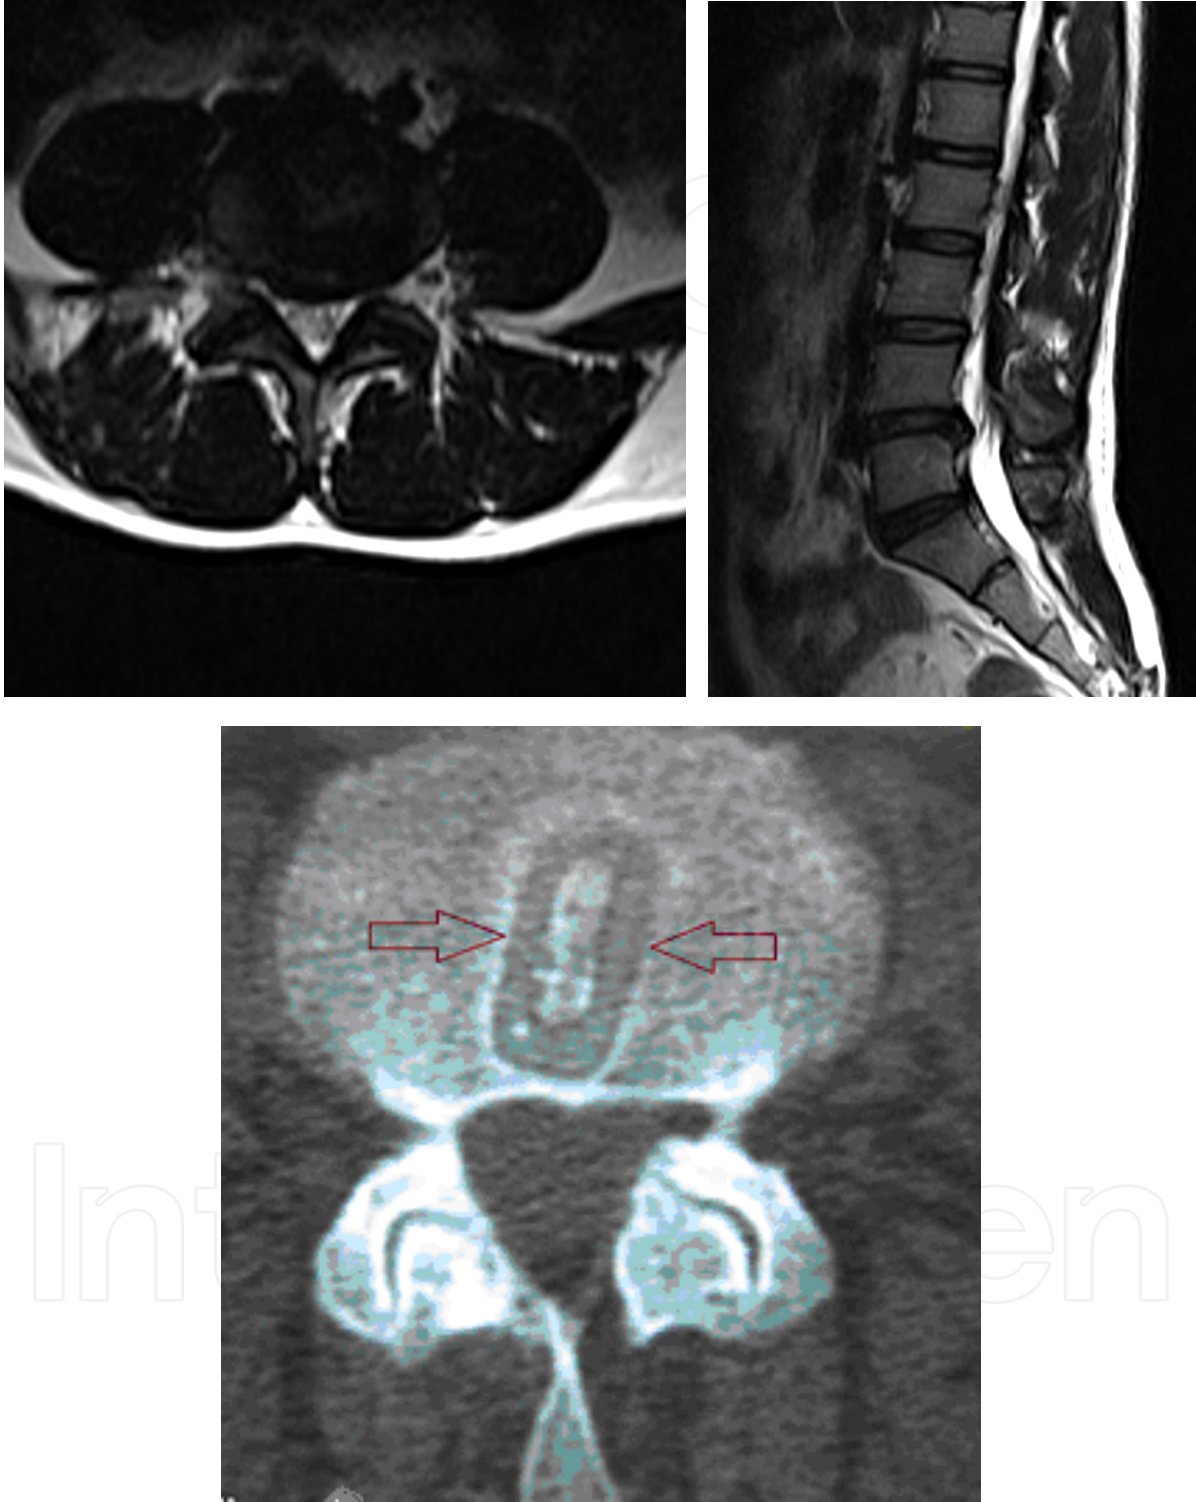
Preoperative MRI and postoperative CT of 52-year old female case with degenerative disc disease were shown: The patient was admitted with left radicular leg pain and numbness. At physical examination loss of left L5 sensation and left dorsoflexion deficit were obtained. She was operated from left side and after discectomy unilateral PEEK cage was placed on L4-L5 levels (Karabekir, 2006). She had no complaint at 5 years follow-up.
